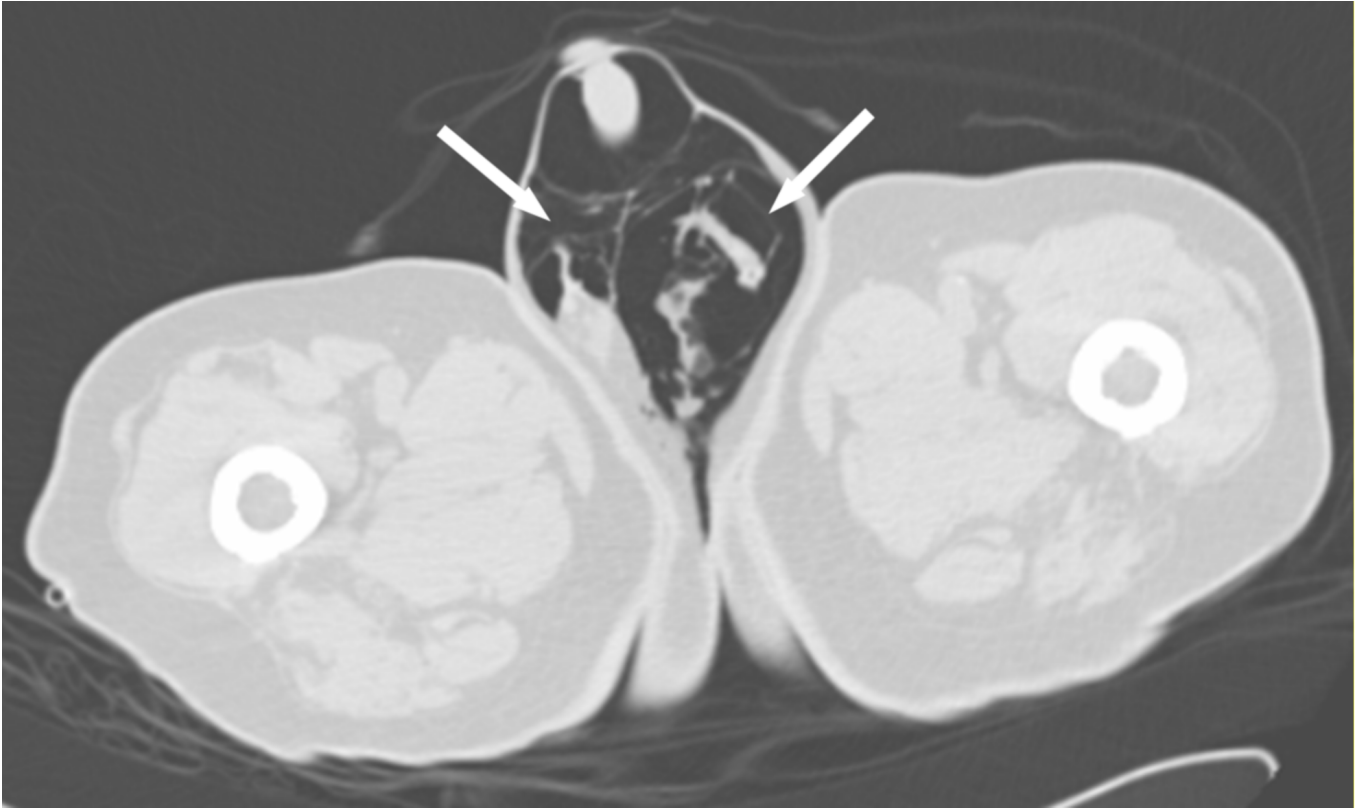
80-year-old man with massive subcutaneous emphysema. CT of perineum shows bilateral intrascrotal air (arrows).
